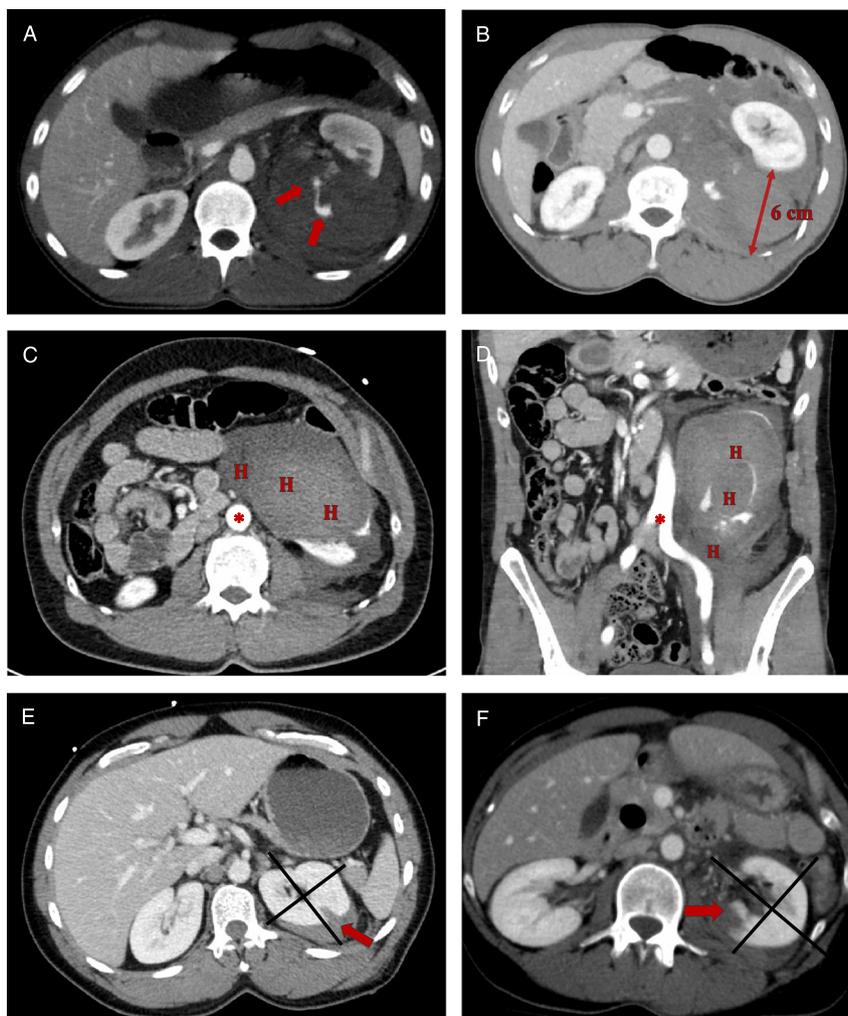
CT findings after high-grade renal trauma. (A) VCE from the left kidney (red arrows), during the arterial phase of the CT scan in the axial plane. (B) Perirenal HRD measuring 6 cm at the axial plane with associated VCE. (C) Anterior pararenal extension of hematoma (letter H) beyond aorta (red asterisk). (D) Extension of left kidney hemorrhage (letter H) inferior to the aortic bifurcation (red asterisk) into the pelvis in the coronal plane. (E & F) Laceration location is defined using a perpendicular line to a plane through the renal hilum to define the medial and lateral halves of the kidney; (E) lateral laceration (red arrow); (F) medial laceration (red arrow).
